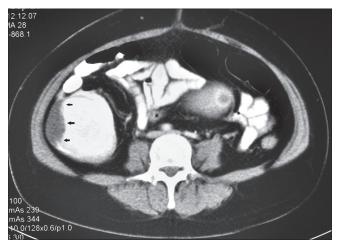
Contrast-enhanced computed tomography abdomen: Well-defined lobulated nonenhancing hypodense lesion in the proximal ascending colon (arrows)
